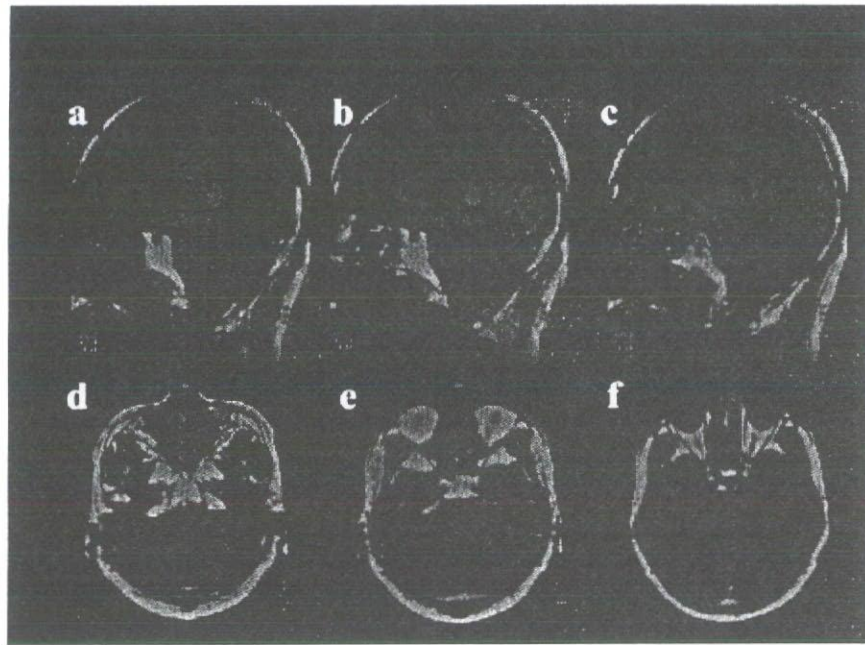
Magnetic resonance imaging of a patient with chromosome 16q22.1-linked ADCA. T1-weighted sagittal (a.-c.) & axial (d.-f.) brain MR images of a 58-year-old male patient 3 years after onset of ataxia. The cerebellar vermis, particularly at its upper aspect, is predominantly affected, while the brainstem is fairly well preserved.
